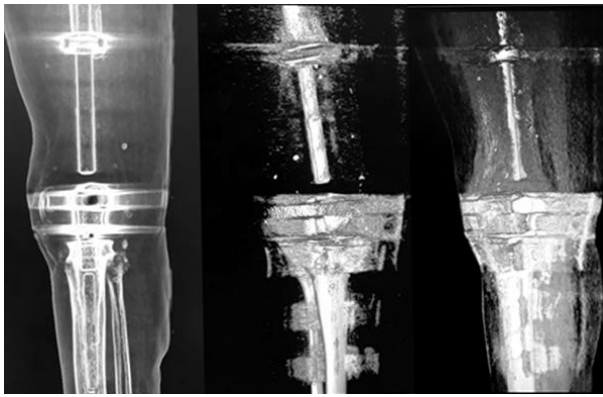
Postoperative immediate left thigh computed tomography (CT), showing position of endoprosthesis
